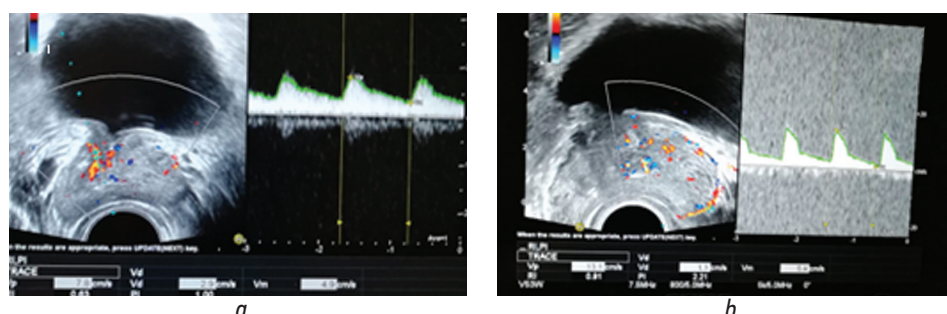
Patient P. (main group). Doppler TRUS of the prostate before treatment: *a* – urethral branches of the artery of the prostate; *b* – capsular branches of the prostate artery
